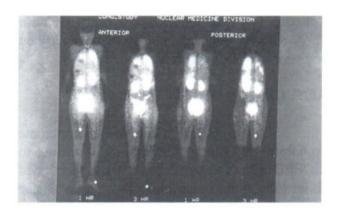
Tc-99m apcitide whole-body planar scintigraphy at 1 and 3 hours post injection. A focus of abnormal uptake at the right lower lung field clearly seen at 3 hours (arrow). Also the other focus at right thigh.
